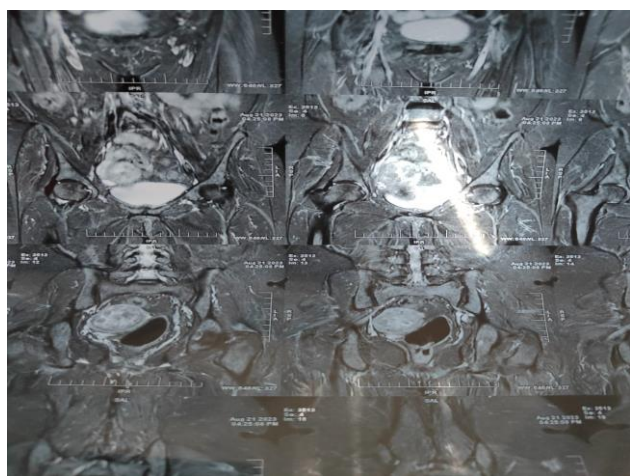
MRI image of large heterogeneously hypointense lesion in fundal region with few hyperintense foci within it.
